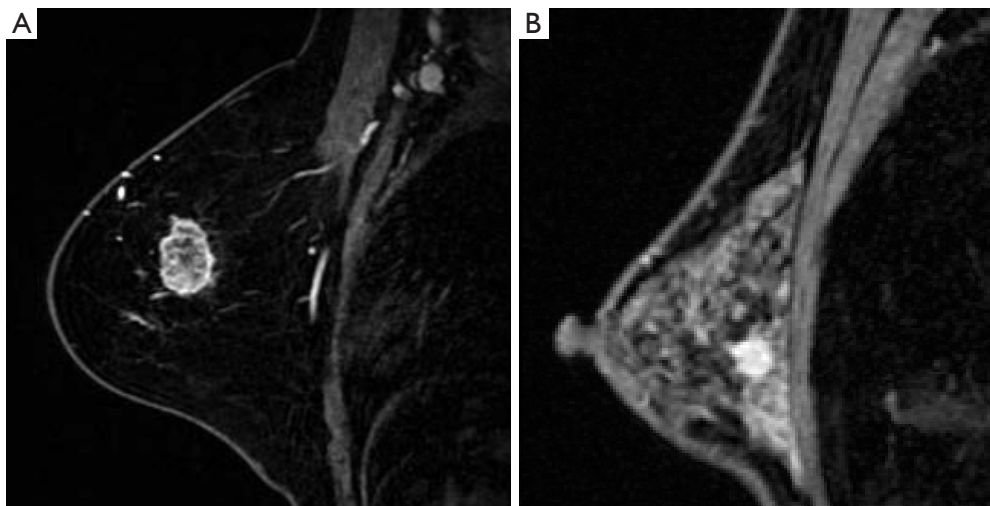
Examples of MRI images in two breast cancer patients. (A) View of a 60-year-old female with IDC reveal a darker glandular background on DCE-MRI, underwent breast-conserving surgery and with final negative margins. (B) View of a 41-year-old female with IDC reveal a more obvious background on DCE-MRI, underwent breast-conserving surgery but with final positive margins. MRI, magnetic resonance imaging; IDC, invasive ductal carcinoma; DCE, dynamic contrast-enhanced.
